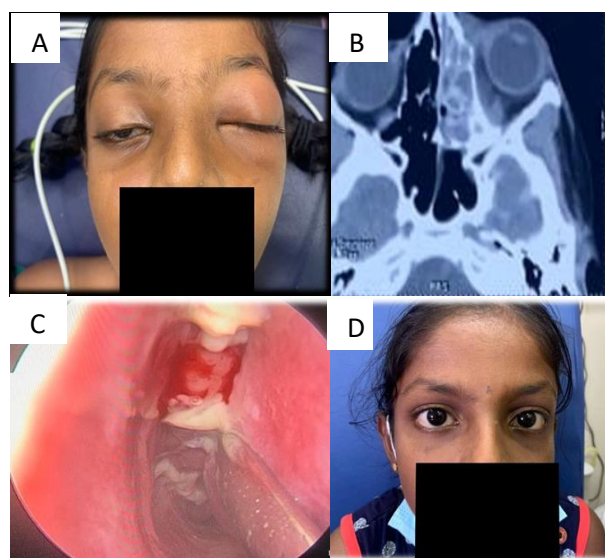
(A) Clinical picture; (B) CT PNS: subperiosteal abscess left eye; (C) transnasal endoscopic orbital & (D) follow up -After 3 weeks decompression (L).
